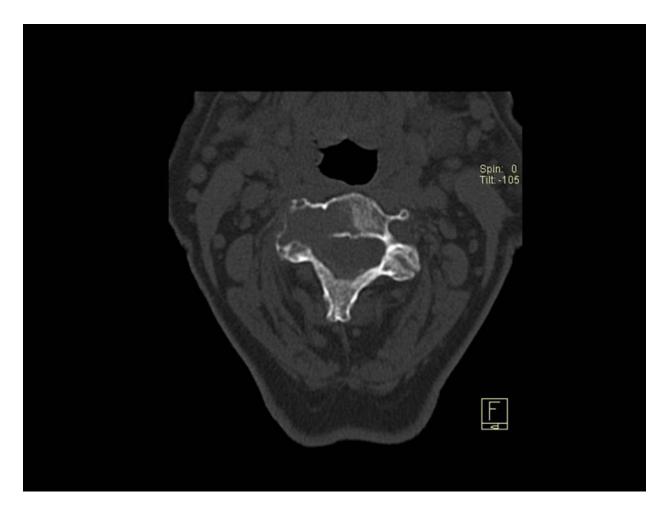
Plasmocitoma. Expansive lytic lesion is seen on computed tomography in the anterior cervical spine. Evident marked erosion, expansion and cortical destruction. No matrix mineralization.
